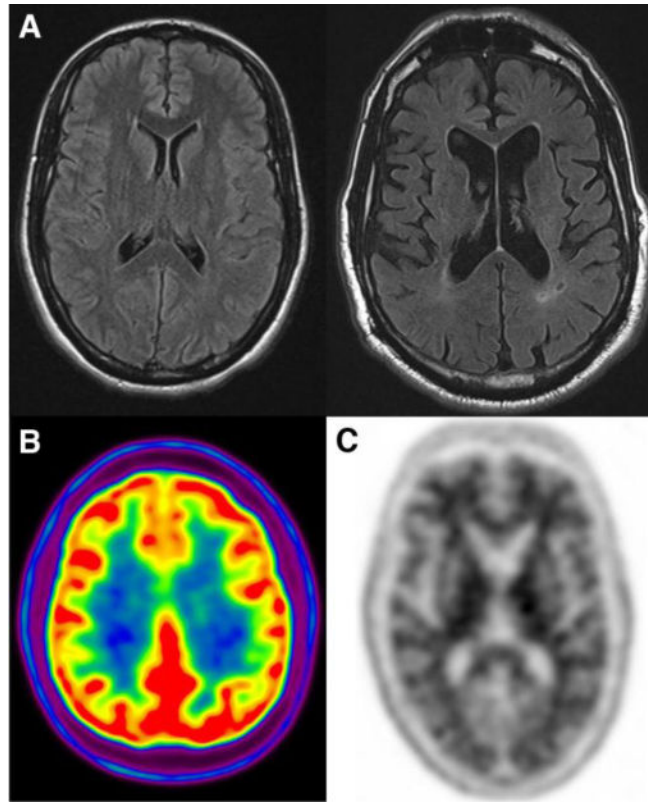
Imaging of cognitively normal individuals. (A) Axial FLAIR shows normal appearance of the brain on MRI in a young adult in third decade and typical appearance of a brain MRI in the eighth decade, showing mild atrophy and mild white matter hyperintensities. (B) Normal ^{18}F -FDG PET shows high uptake in gray matter structures. (C) Normal amyloid PET scan with the radiotracer ^{18}F -florbetapir shows typical white matter uptake but no evidence of elevated cortical binding.
